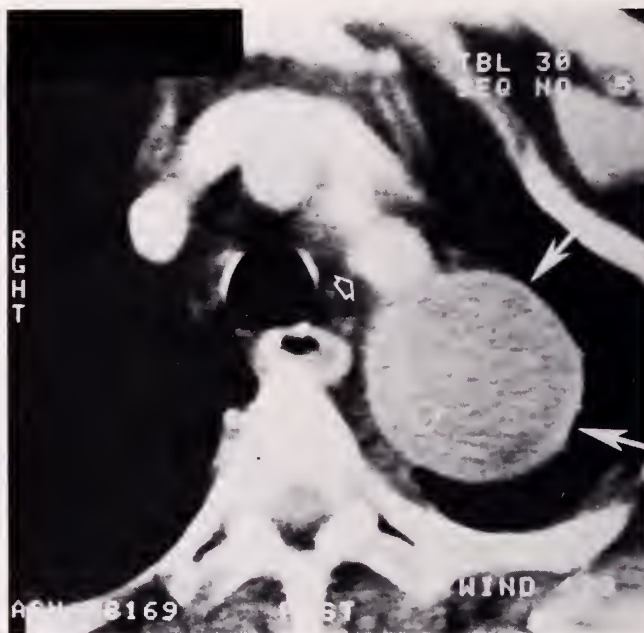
Contrast enhanced CT section obtained just above the level of the arch of the thoracic aorta demonstrates a non-enhancing mass (arrows) adjacent to the left subclavian artery (open arrow).
